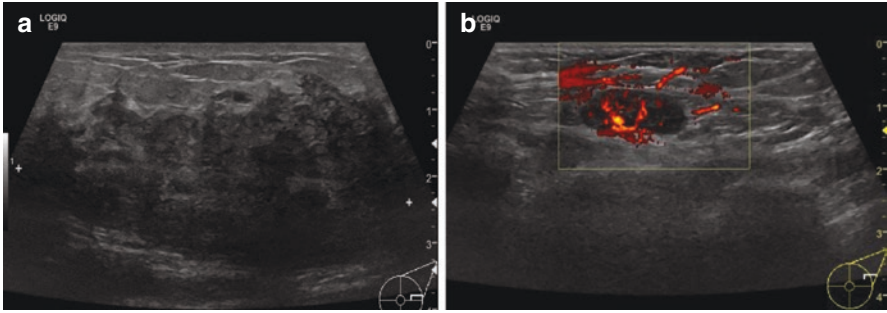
(a) A 31-year-old woman presenting with a 5-day history of left breast swelling and pain. On ultrasound, there is a large 65-mm inflammatory mass occupying the lateral aspect of the left breast with no obvious collection. (b) Hypervascular enlarged nodes are also present. Core biopsy showed features in keeping with chronic mastitis with no granulomas
